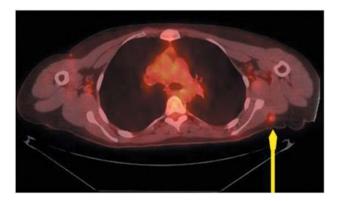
PET-CT showing two hyperactive lesions at the level of the right shoulder.
